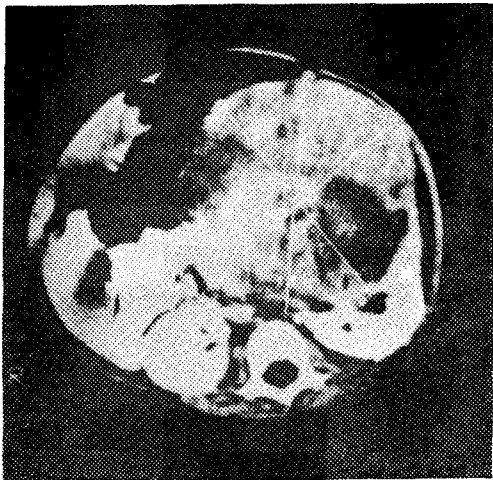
e) Post contrast CT showed ; heterogenous enhancement of the mass.
